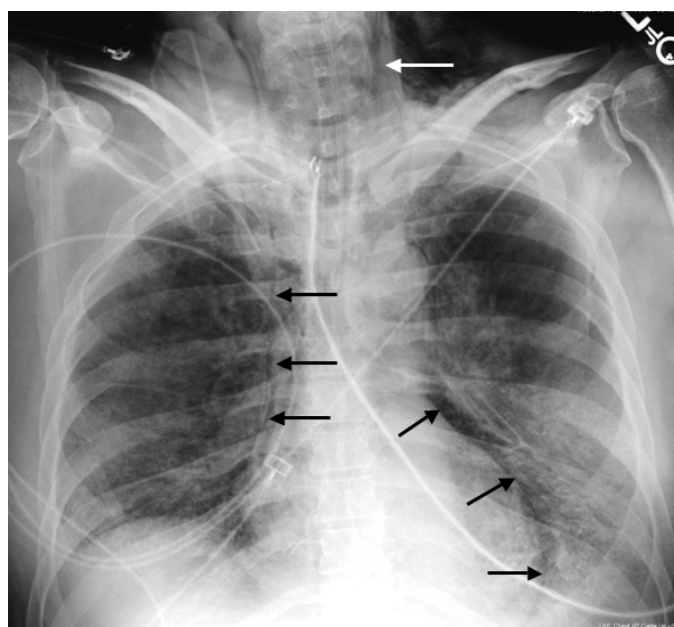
AP chest radiograph reveals pneumomediastinum (long black arrows), subcutaneous emphysema (long white arrow), and bibasilar reticulonodular ground-glass opacities. Note the wide lucency projecting over the left cardiac border consistent with pneumomediastinum (and/or medial pneumothorax?), in contradistinction to Mach effect.
